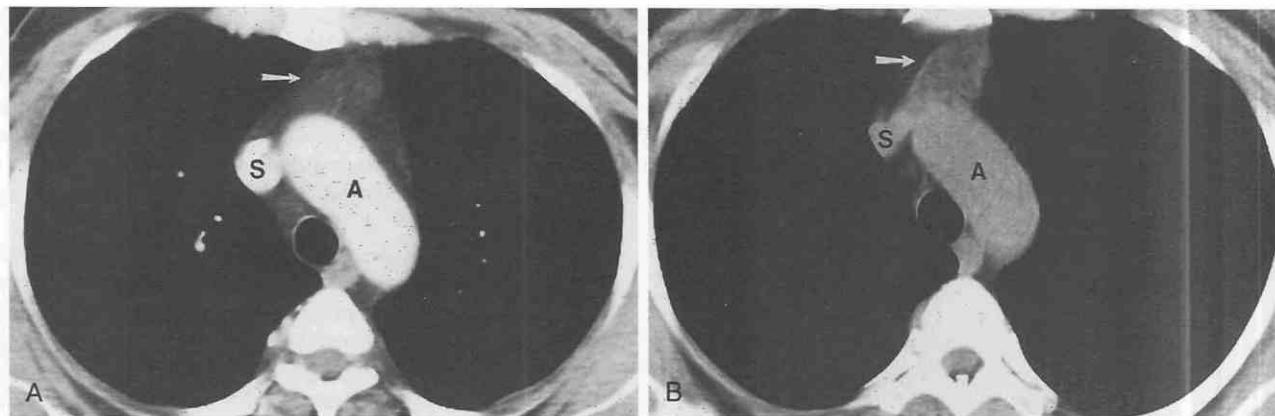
Thymus gland in a 42-year-old woman with breast carcinoma. *A*, Contrast-enhanced CT shows fatty replacement of thymus gland. Residual thymic tissue manifests as linear areas of soft tissue in anterior mediastinal fat (arrow). *B*, Non-contrast-enhanced CT 6 months after bone marrow transplantation shows increased soft tissue in anterior mediastinum, consistent with thymic hyperplasia (arrow). A, aorta; S, superior vena cava.
